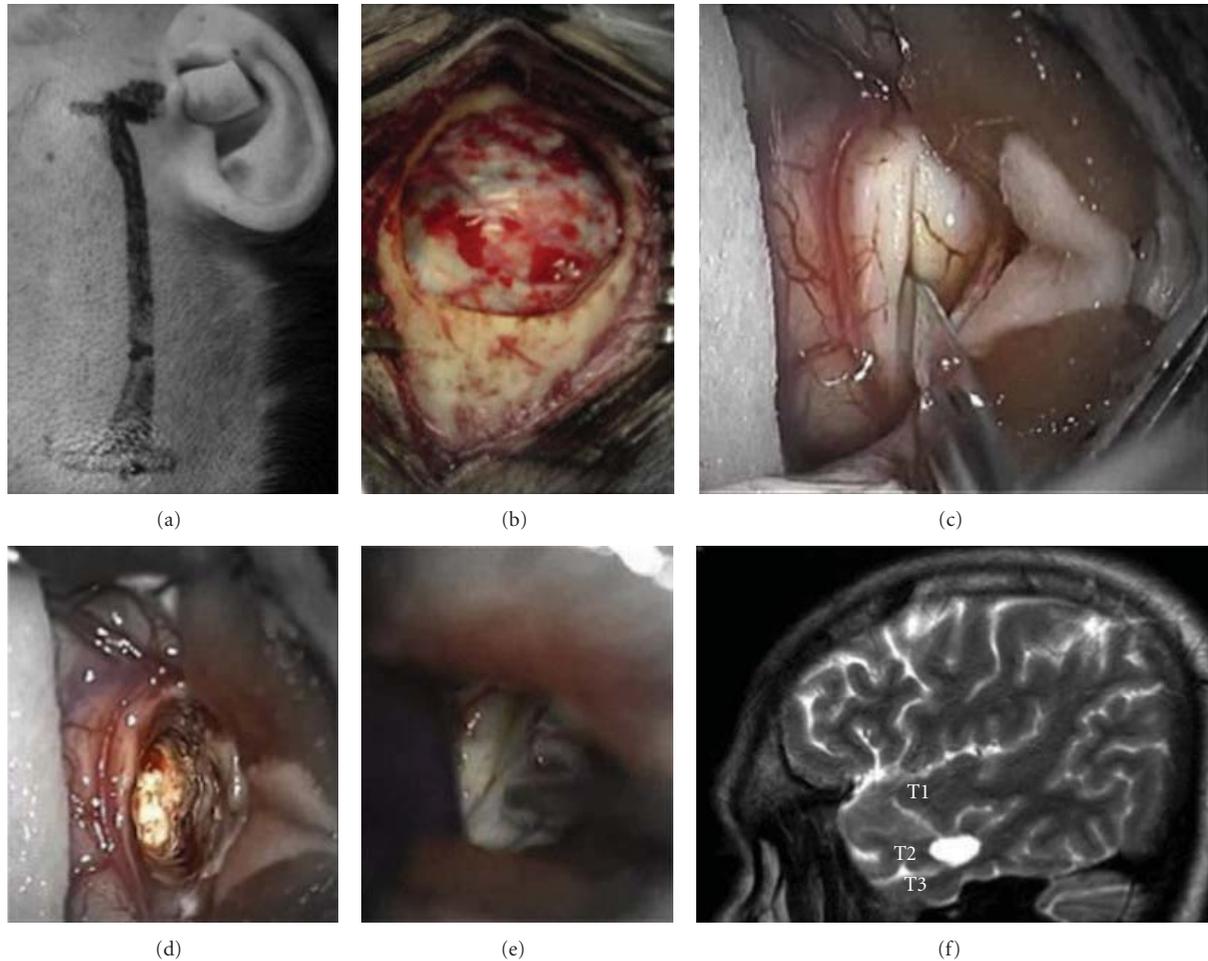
(a) Intraoperative photograph showing site of skin incision for selective amygdalohippocampectomy. (b) Minicraniotomy and dura exposure. (c) Corticectomy at middle temporal gyrus (T2). (d) Transcortical access to temporal horn. (e) Hippocampus exposure. (f) Postoperative sagittal T2 MRI depicting the transcortical access through middle temporal gyrus.
